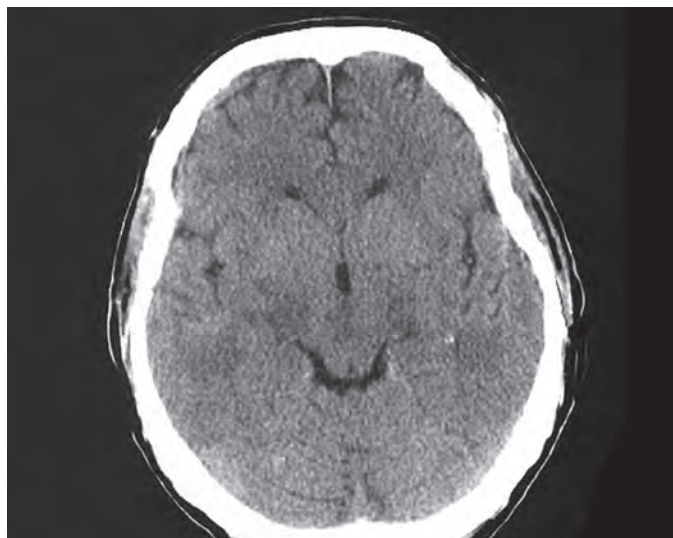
CT of the brain without contrast shows no signs of infarction or hydrocephalus following the second operation
